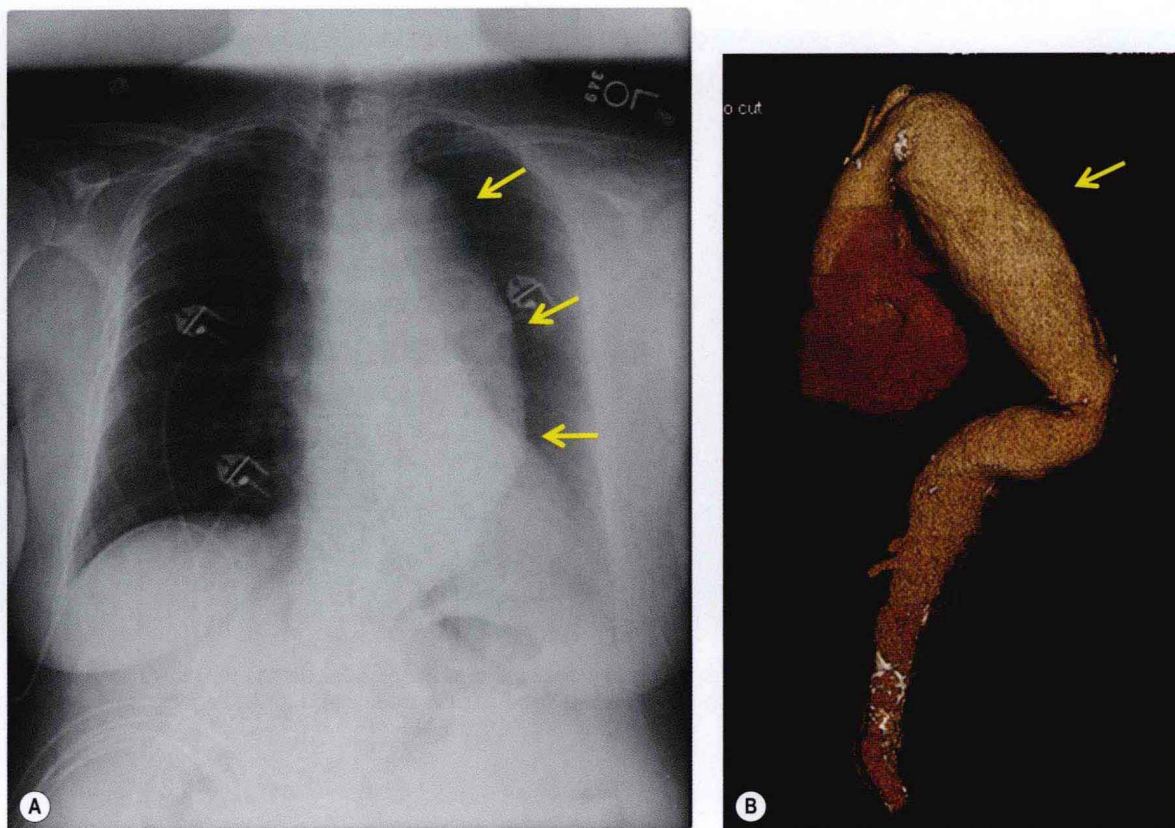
Aortic aneurysm. A, Chest radiograph shows enlarged and tortuous aorta (arrows) in a patient with chest pain. B, Surface shaded reconstructions of emergency CT show large aneurysm of the aortic arch and the descending aorta (arrow).
